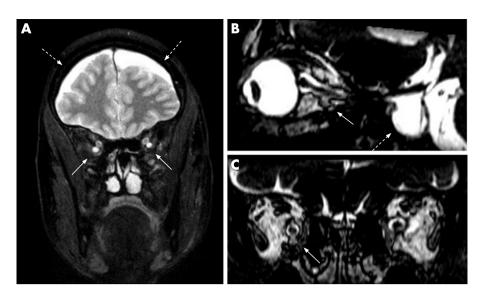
Magnetic resonance images showing aneurysm-like ectasias (solid arrows) of the optic nerve sheaths, subdural haematomas (dotted arrows in (A)), and empty sella (dotted arrow in (B)). (A) T2 weighted image with fat suppression. (B) (C) Multiplanar reconstruction of a three dimensional T2 weighted sequence in sagittal (B) and coronal projection (C).
